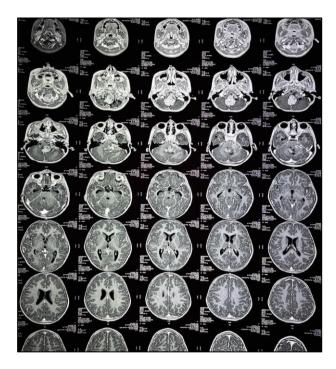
MRI brain -showing findings most likely suggestive of malignant neoplastic etiology likely posterior fossa ependymoma.
